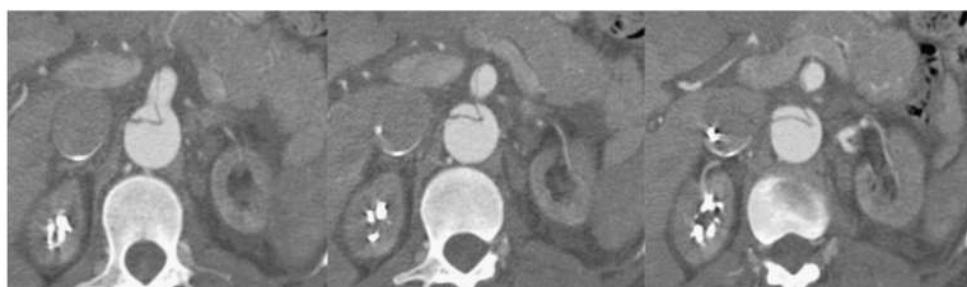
Static branch vessel involvement of the superior mesenteric artery (SMA) is evident on these axial computed tomography images from a patient with acute dissection. Anatomically, this branch vessel complication occurs when the intimal flap of the dissection extends directly from the aorta into one of its branches. Depending on a number of factors, this branch involvement may be associated with clinical symptoms and ischemic sequelae. In this case, the aortic true lumen is small and located ^{anterior} to the dissection septum. The dissection septum intersects the SMA and extends into the branch, bisecting the artery, and creating dual channel or "double barrel" flow in the vessel. The resultant diminutive true channel hugs the right side of the branch as it courses distally.
